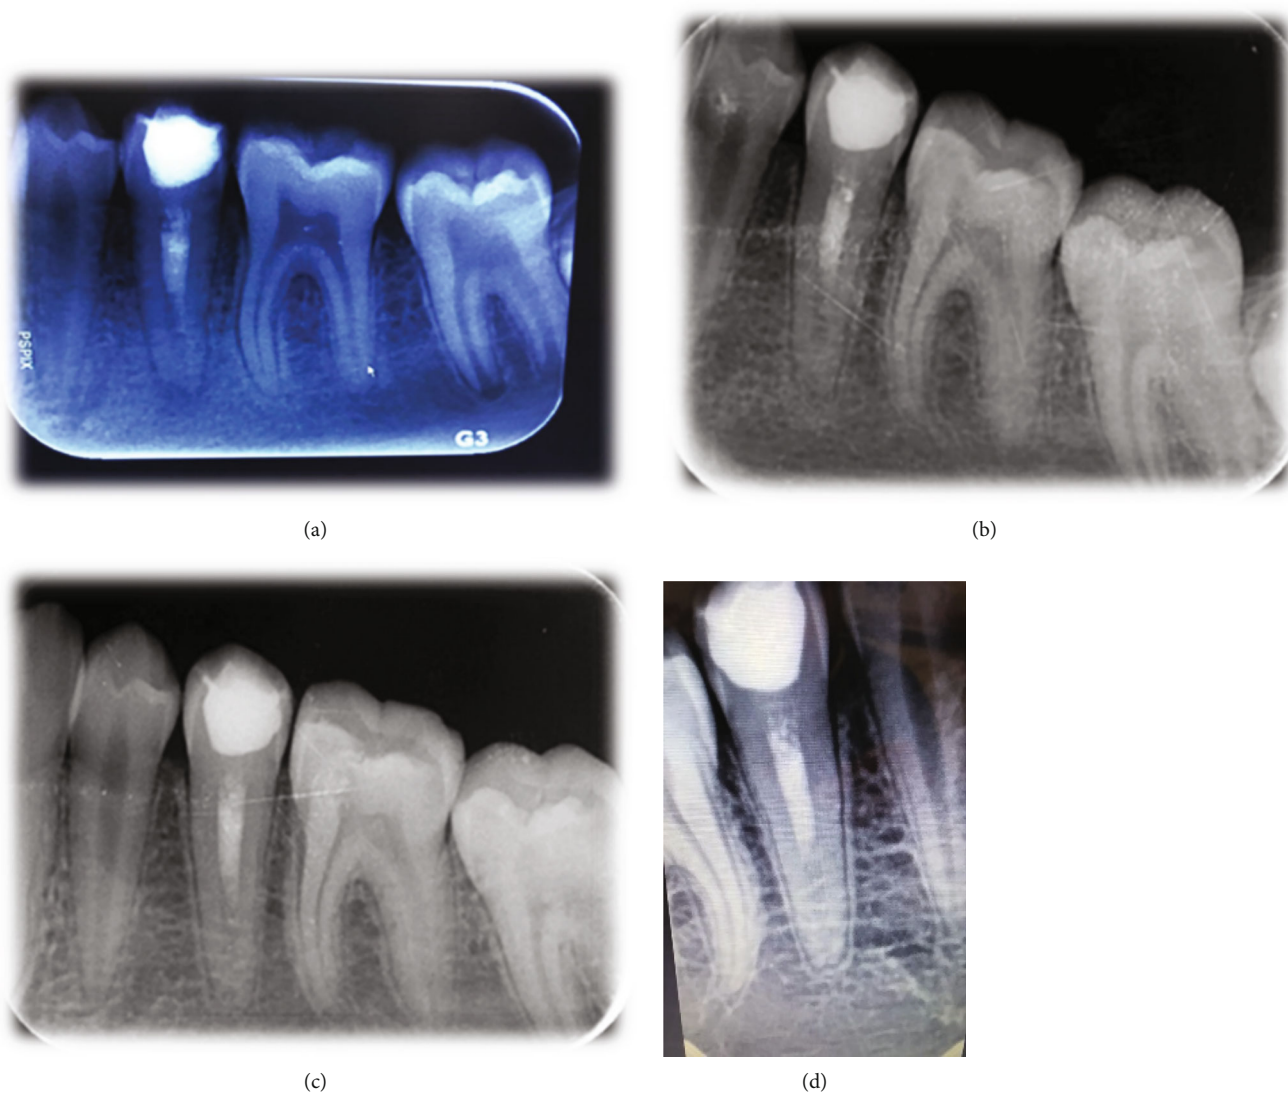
The periapical radiograph during follow-ups at months 3 (a), 6 (b), 12 (c), and 24 (d).
